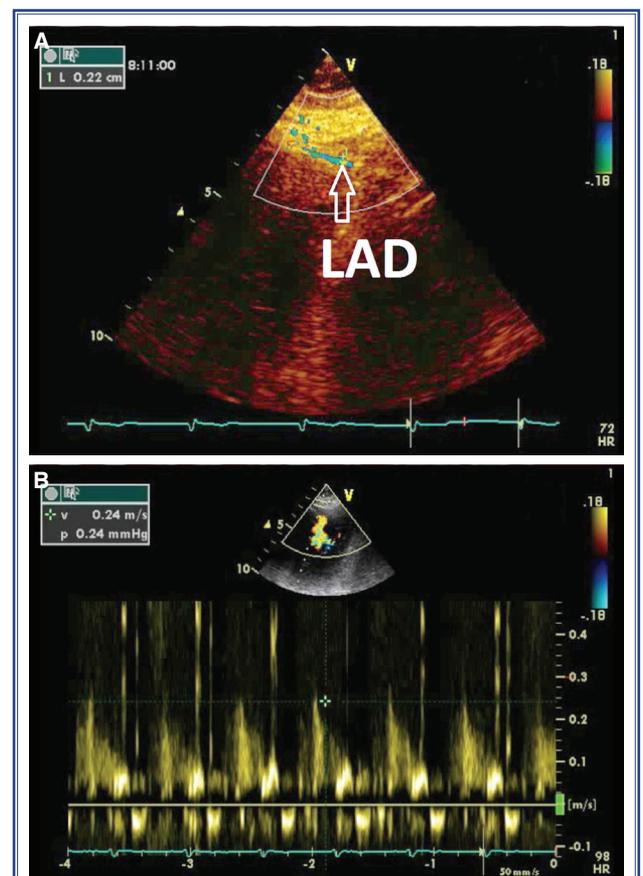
Assessment of CFR. (A) Mid to distal segment of the LAD coronary artery in color-coded transthoracic Doppler echocardiography. (B) Spectral Doppler coronary blood flow in mid to distal segment of the LAD.
